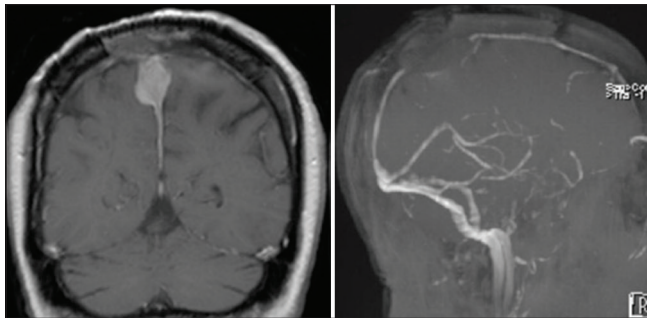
Preoperative imaging studies. Coronal T1 postcontrast MRI demonstrating recurrent progressive atypical meningioma (Left). 3D sagittal reconstruction of MRV demonstrating occlusion of middle/posterior third of the superior sagittal sinus (Right).
